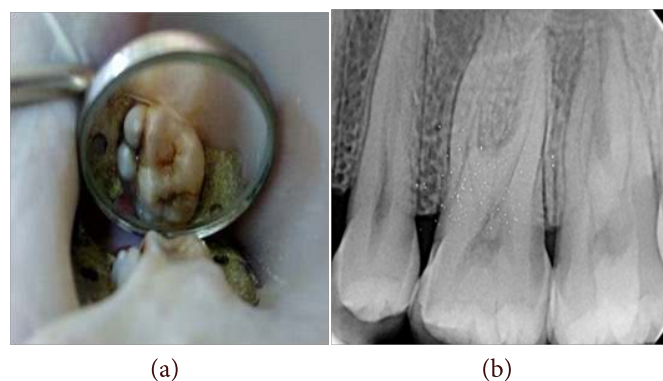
(a) pre-operative picture (b) pre operative radiograph
